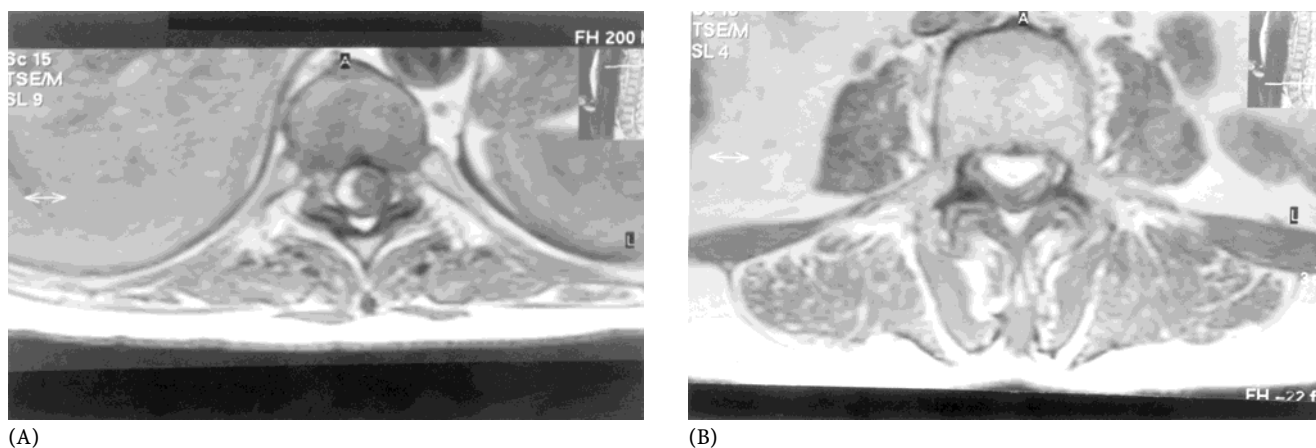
Transverse T1-weighted MRI scans of the spine, demonstrating a subdural haematoma appearing: (A) as a semicircular right ventrolateral collection at the level of T10, (B) as a pure ventral collection at the level of L4
